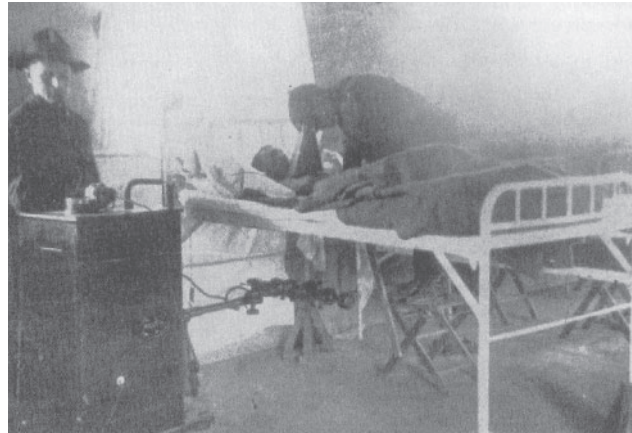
The Waite and Bartlett Army bedside unit, shown at the base hospital in Grand Blottereaux in 1915, was the first stock x-ray equipment that used a Coolidge hot-cathode tube. The examiner looked into a cryptoscope, the hand-held fluoroscope.
